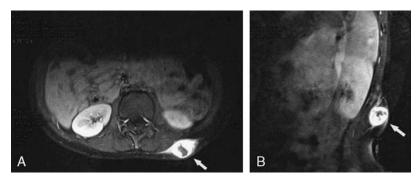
A and B, Subcutaneous mass with contrast enhancement on magnetic resonance imaging (white arrow) on axial plane and sagittal plane.
